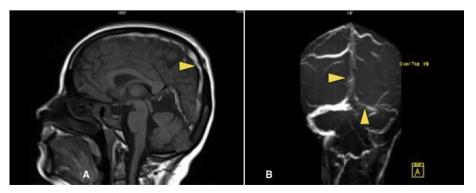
Sagittal T1-MRI (A) and MRV (B) scans demonstrating extensive filling defects in the superior sagittal and left transverse sinuses (arrowheads).
